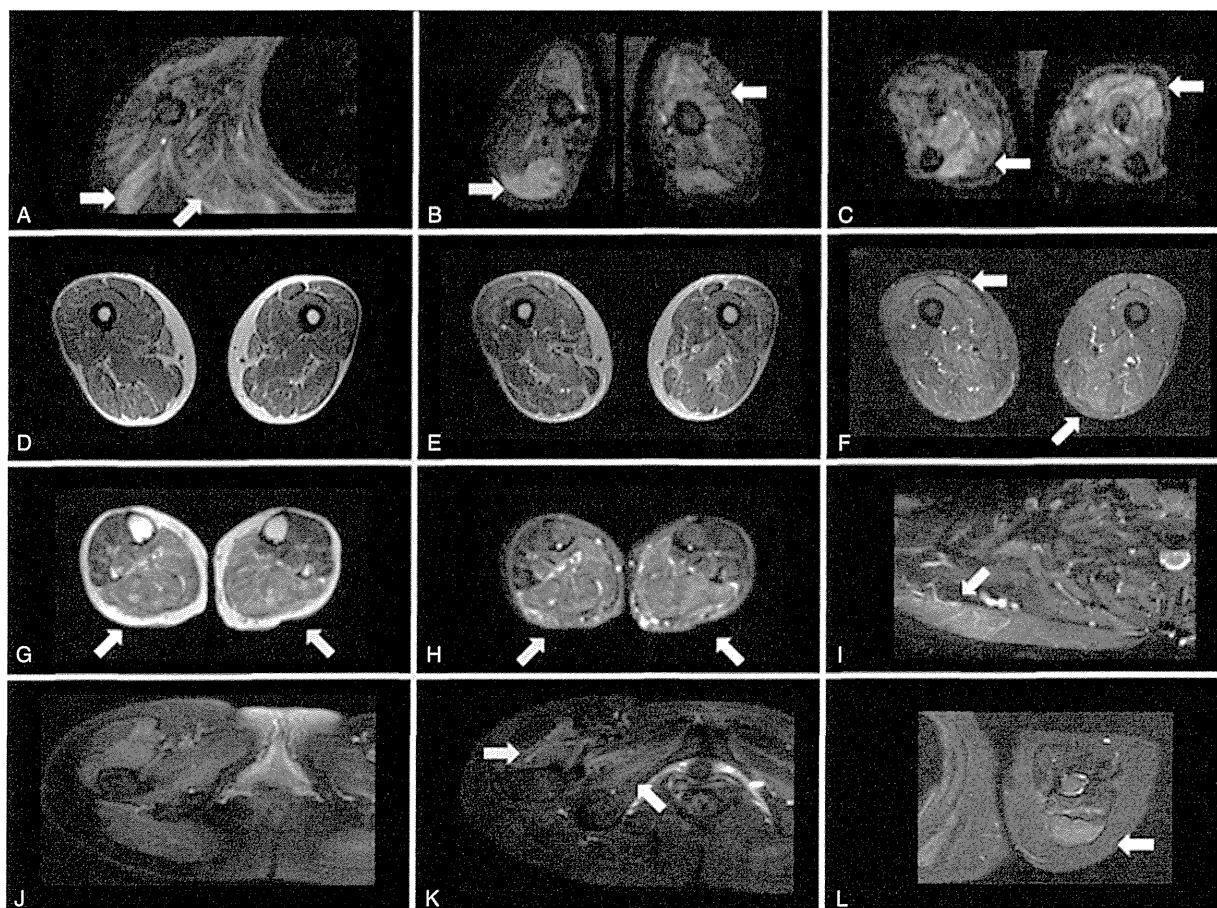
Muscle MRI of patients with anti-HMGCR antibodies. (A–C) Patient 2. Increased short T1 inversion recovery (STIR) signal abnormalities involving deltoid, infraspinatus muscles (A), biceps brachii and triceps brachii (B), and forearm muscles (C). (D–F) Patient 3. Images of thighs on T1 images (D), T2 images (E), and STIR images (F). High intensity in biceps femoris and semitendinosus muscles on STIR images. (G, H) Patient 4. Increased T2/STIR signal abnormalities in posterior calves. (I) Patient 6. Increased STIR signal in trapezius muscle. (J–L) Patient 7. STIR images of pelvis (J) and enhancement in vastus lateralis and obturator internus muscles (K). Increased signal with enhancement of triceps brachii on STIR images (L).
